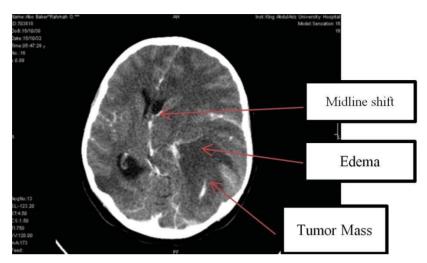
CT brain showed left parietooccipital large intraparenchymal space – occupying lesion with significant midline shift.
